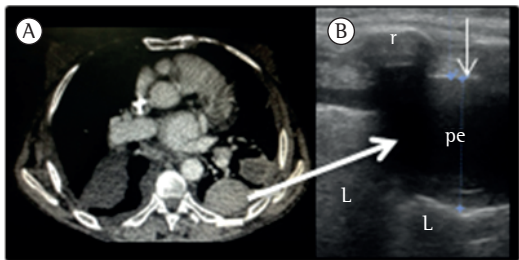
CT (in A) and ultrasound (in B) revealing loculated pleural effusion. pe: pleural effusion; L: lung; and r: rib. The thin arrow indicates the parietal pleural line.
